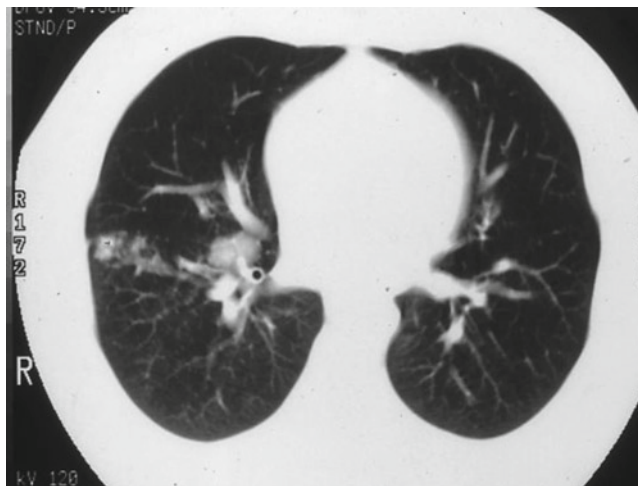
CT scan of a patient with acute pulmonary histoplasmosis. Note hilar adenopathy and patchy pneumonitis
